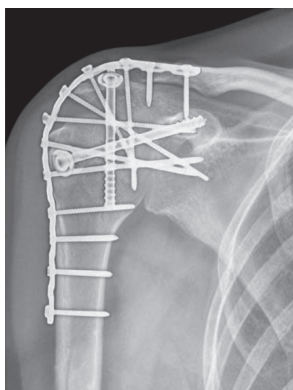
X-ray: Shoulder arthrodesis with reconstruction plate and screw
